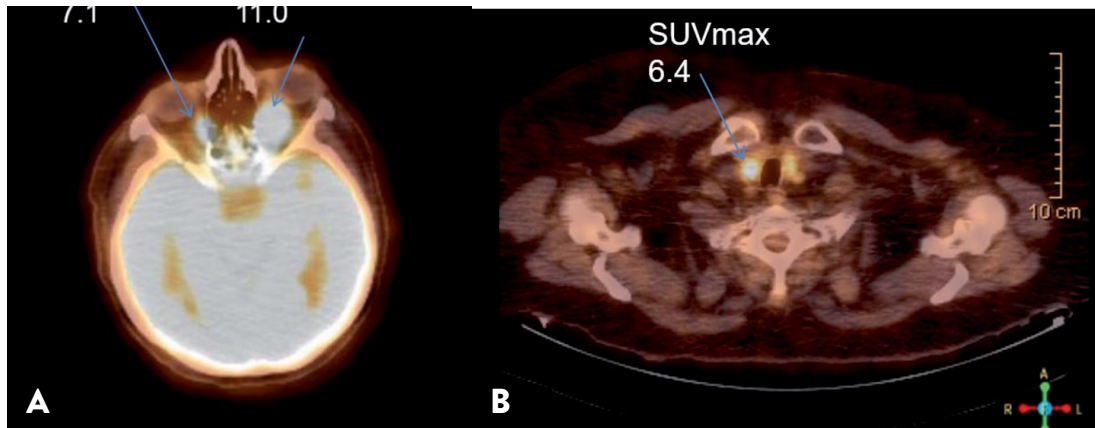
^{18}F -FDG PET/CT scan: (a) increased ^{18}F -FDG uptake in the expansive mass within bilateral medial rectus muscles; (b) increased ^{18}F -FDG uptake in the thyroid gland.
